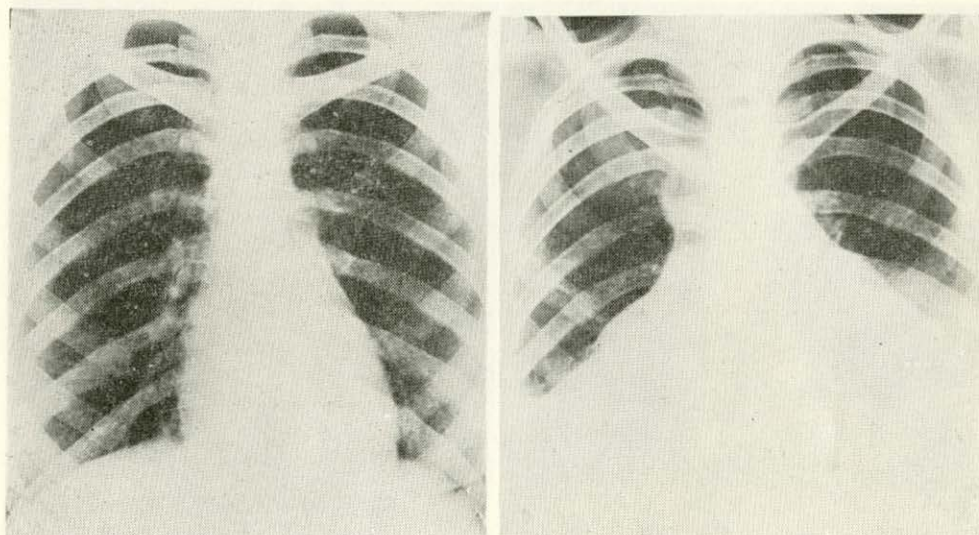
(Cont'd) C. Chest x-ray shows no abnormalities. D. Five months later, fluid in both pleural cavities and pericardium; soft round infiltration in right upper lobe; linear, horizontal striations in right midlung. (Autopsy revealed fibrinous, gelatinous, exudate in both pleural cavities, also in pericardial sac). Edema and congestion of lung parenchyma; glomerular lesions of kidney with suggestive "wire-loop" appearance).
